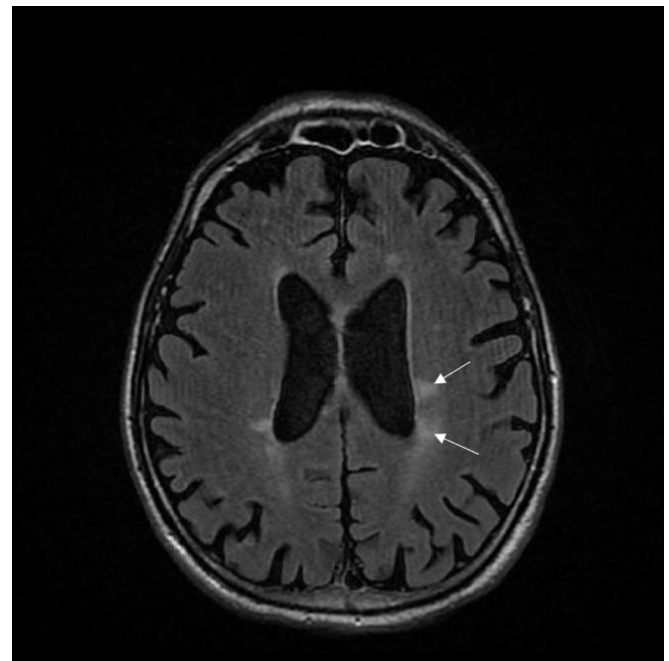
Magnetic resonance imaging (MRI) after fingolimod treatment shows a reduction of demyelinating lesions. Axial MRI, T2- weighted image showing periventricular lesions and subcortical foci in the centrum semiovale (arrows).
